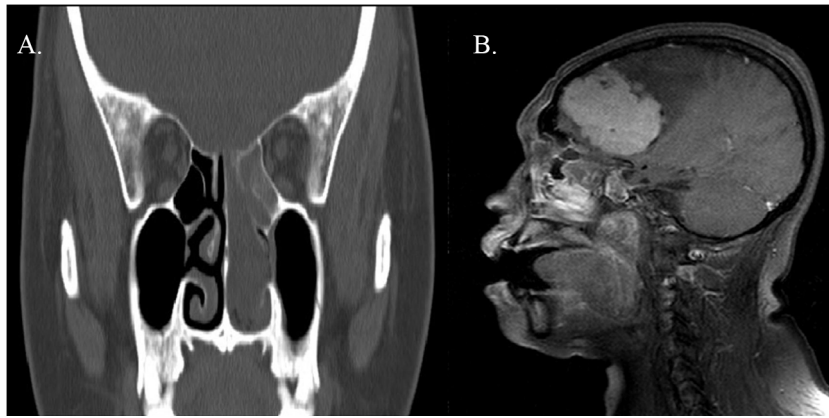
Pre-operative CT images. (A) Image with coronal section shows intensely enhancing mass in left ethmoid sinus, extending to the cribriform plate. (B) Sagittal section shows brain tumor and sinonasal tumor, which arise from skull base defect.
